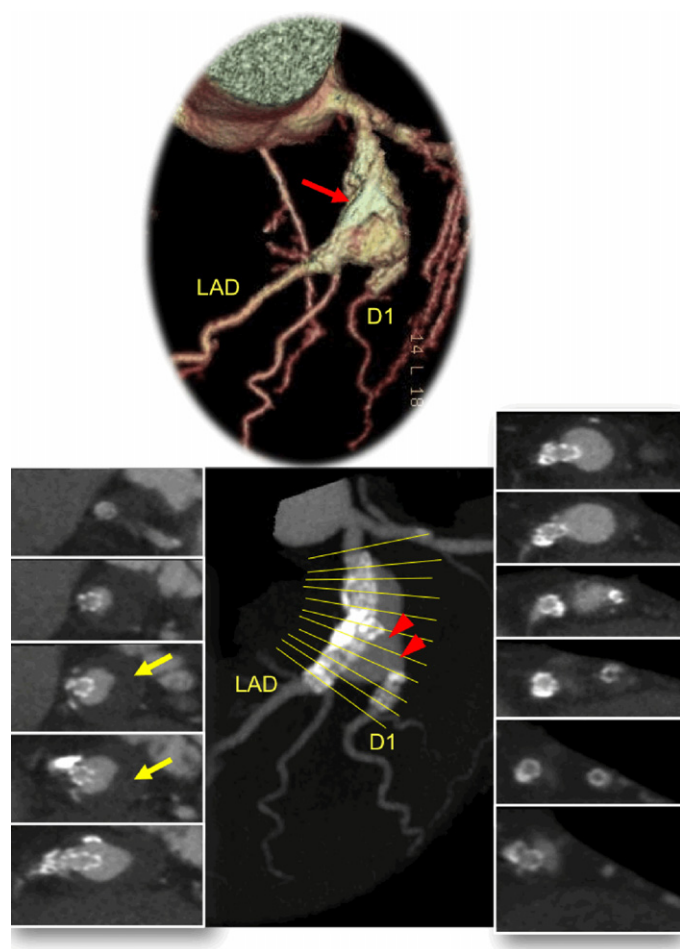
The volume-rendered (upper panel) and curved and axial multiplanar reformation images (lower panels) of coronary computed tomography (CT). Coronary CT demonstrated a giant coronary aneurysm (19 mm in diameter, 29 mm in length) (red arrow) with stent malapposition and thrombus (yellow arrow) at the stented site of left anterior descending artery (LAD). CT also showed the reopened D1 as well as the stent fracture at D1 (arrow head), suggesting that D1 occlusion would be caused by stent fracture and giant coronary aneurysm.
